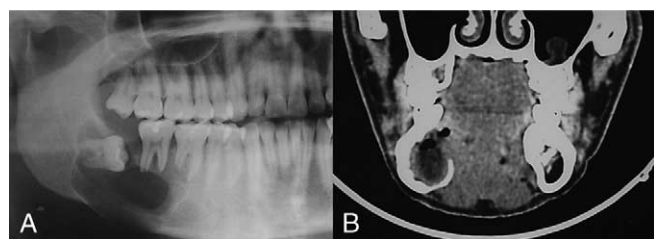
A, Panoramic radiograph showing the lesion in the region of the right mandibular angle with associated third molar, resorbing the roots the teeth 46 and 47. B, Coronal CT scan showing the involvement of the lingual cortex.
